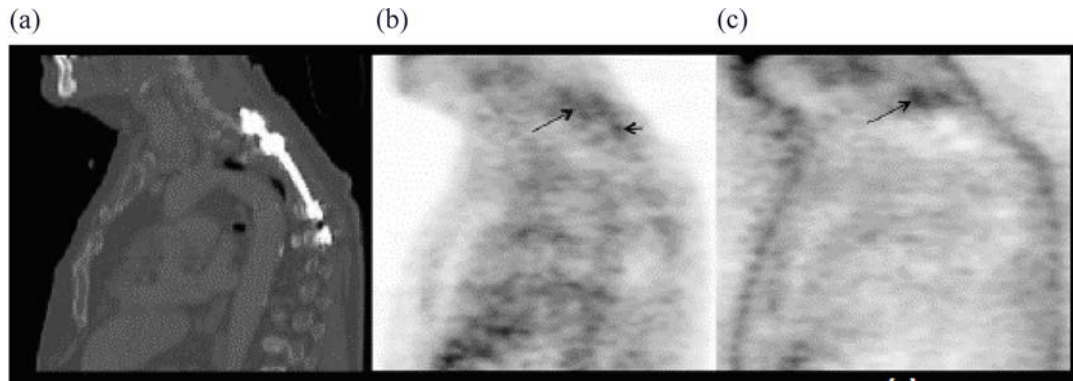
Sagittal sections of the upper torso in CT (a), AC-PET (b) and noAC-PET (c) of a patient with an upper spine orthopaedic brace. The inflammatory changes in tracer uptake (arrow) that are present in (b) and (c) should be noted. The dorsal uptake pattern (arrow-head) is affected more by an overestimation of the attenuation map and is, therefore, only noticeable on AC-PET (b). AC: attenuation corrected; noAC: not attenuation corrected.
